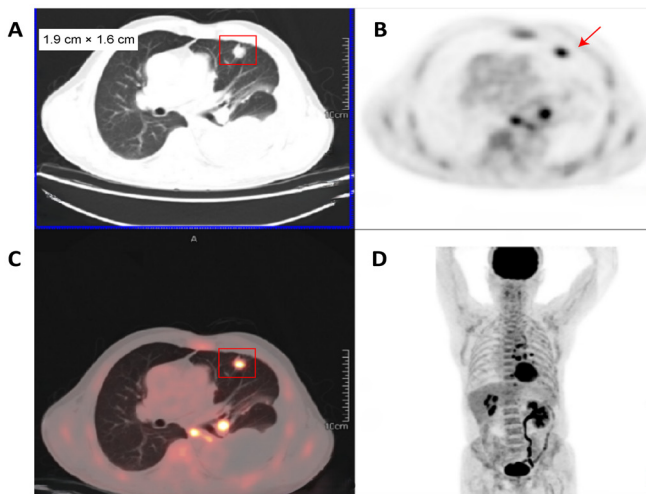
CT and PET/CT images of lung adenocarcinoma in an 81-year-old patient. (A) Pulmonary CT scan performed in October 2020 showing a nodule measuring 1.9x1.6 cm in the lingual segment of the upper lobe of the left lung, indicated by a red box. (B) PET scan indicating metabolic activity in the same area, marked by a red arrow. (C) Combined PET/CT scan corroborating the nodule's location in the left lung, also indicated with a red box. (D) Whole-body PET scan revealing multiple pleural and lymph node metastases, as well as bone metastases. PET, positron emission tomography; CT, computed tomography.
